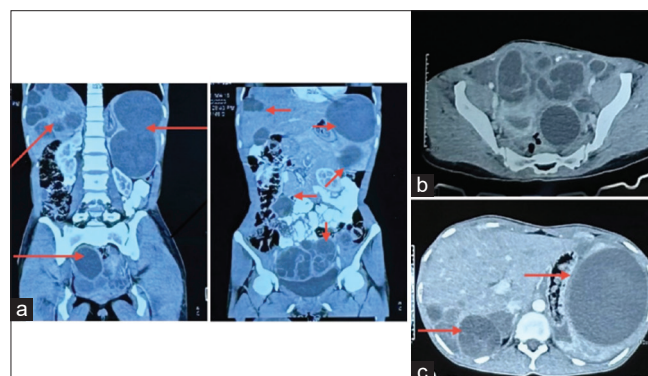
Contrast-enhanced computed tomography of the abdomen and pelvis in coronal (a) and axial sections (b) shows multiple cystic lesions in the liver, spleen, peritoneal cavity, and the pelvic cavity
